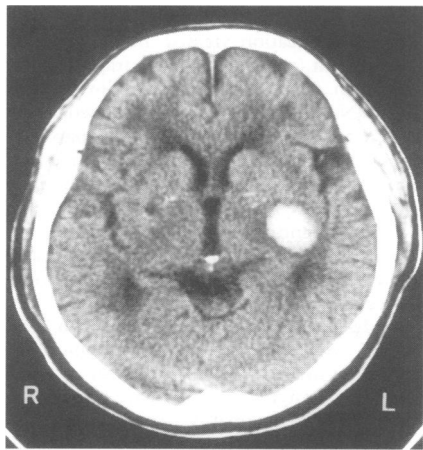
Cranial CT on admission, showing a high density area in the left putamen.
